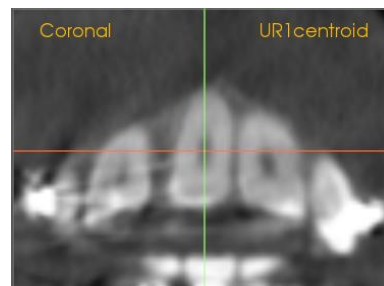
Apex point on six anterior teeth in CBCT and locating the apex point in all 3 planes of space in CBCT. A, Axial view. B, Sagittal view. C, Coronal view.
